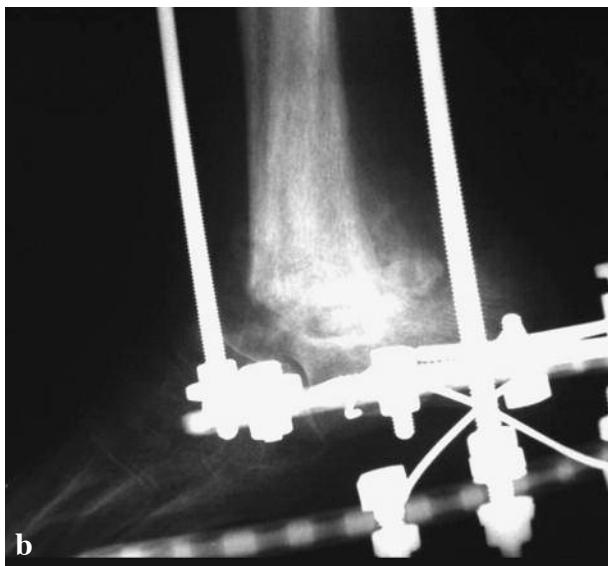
Case no. 8 a) preoperative radiograph : A-P view showing complete ankle joint destruction and dissolution of talus. b) postoperative radiograph : lateral view showing full bony fusion before frame removal. c) clinical photograph with full weight bearing before frame removal.
